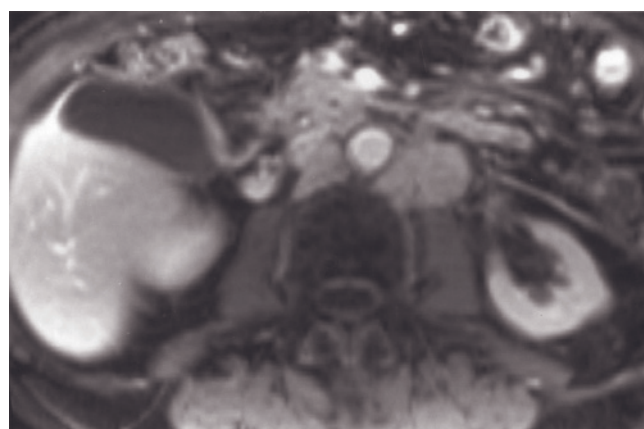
Malignant retroperitoneal lymphadenopathy. Coronal T2-weighted SS-ETSE (a), transverse fat-suppressed T2-weighted SS-ETSE (b), coronal SGE (c), and interstitial-phase gadolinium-enhanced fat-suppressed SGE (d) images in a patient with gastric adenocarcinoma. There is a large, mildly heterogeneous lobulated mass involving the lesser curvature and extending into the gastrohepatic ligament (d). Extensive retroperitoneal lymph nodes are also appreciated. Coronal SGE (e), immediate
